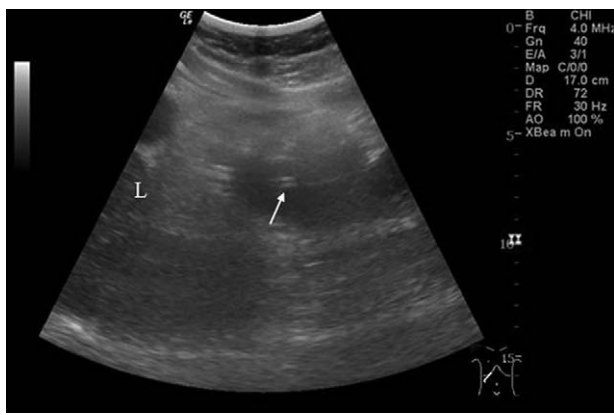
Ultrasound images showed nasojejunum tube (arrow) as a fine and slightly hyperechoic structure in the second portion of the duodenum. Nasojejunum tube in the duodenum (the white arrow). L=liver.
